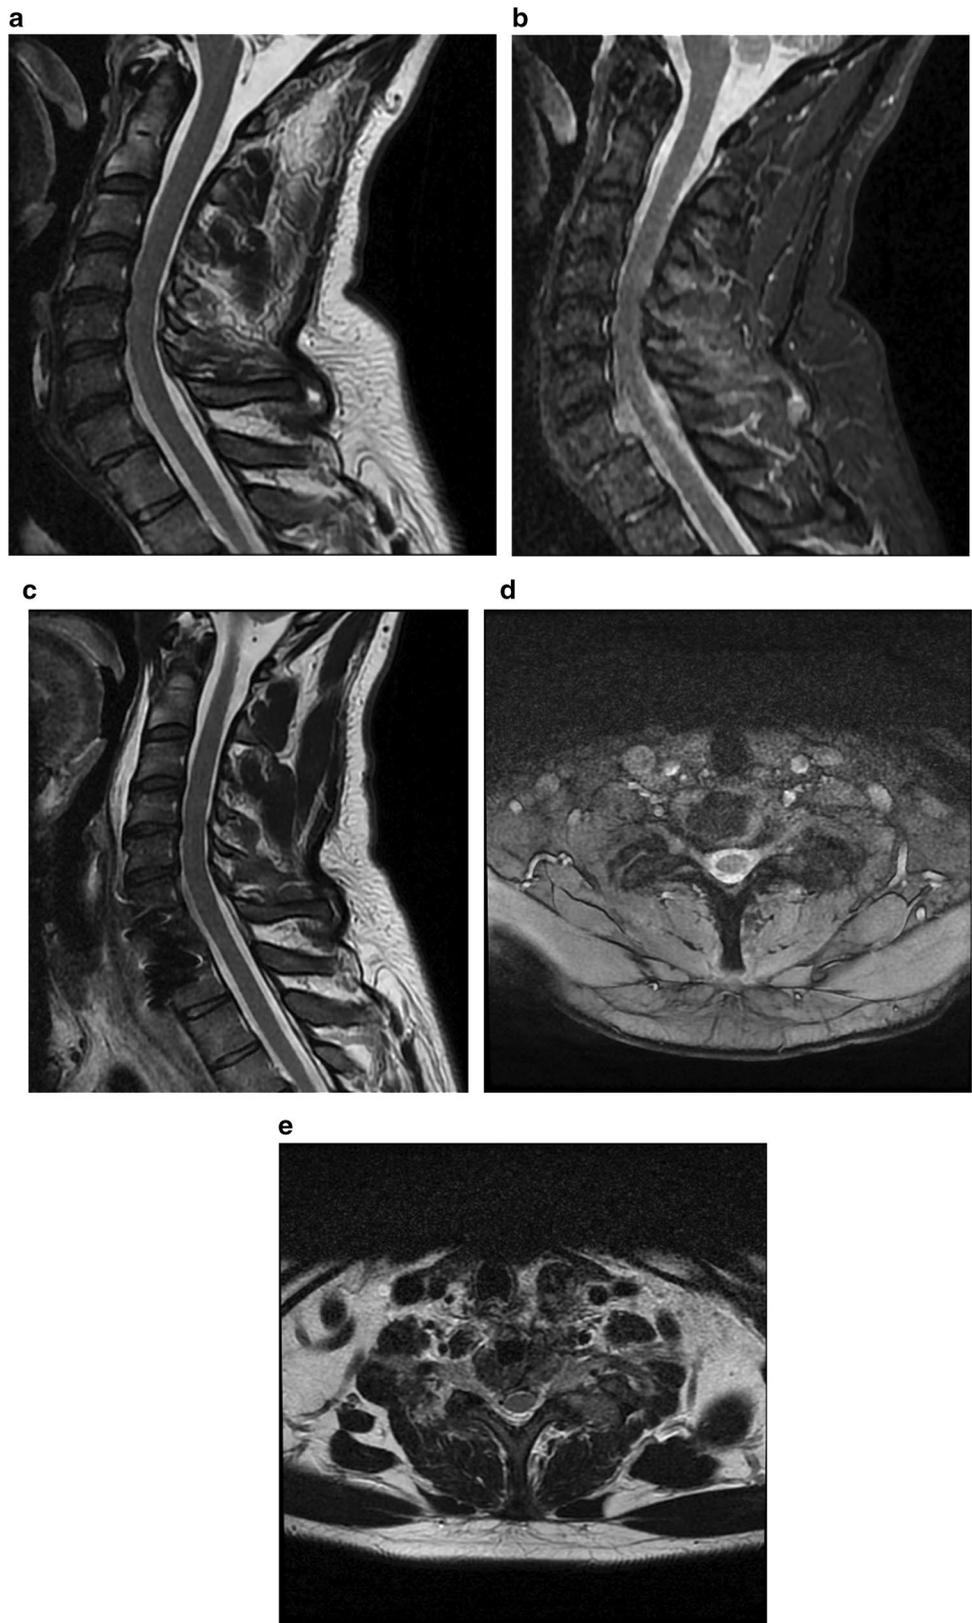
MRI of patient E.: a sagittal projection before surgery T2 weighted image; b sagittal image before surgery T2 weighted image STIR—complete disruption of the posterior capsuloligamentous structures (indicated by arrow); c sagittal projection after C7 corpectomy with expandable cage implantation; d axial image at C7-Th1; e post-operative axial image at C7-Th1, without neural compression
